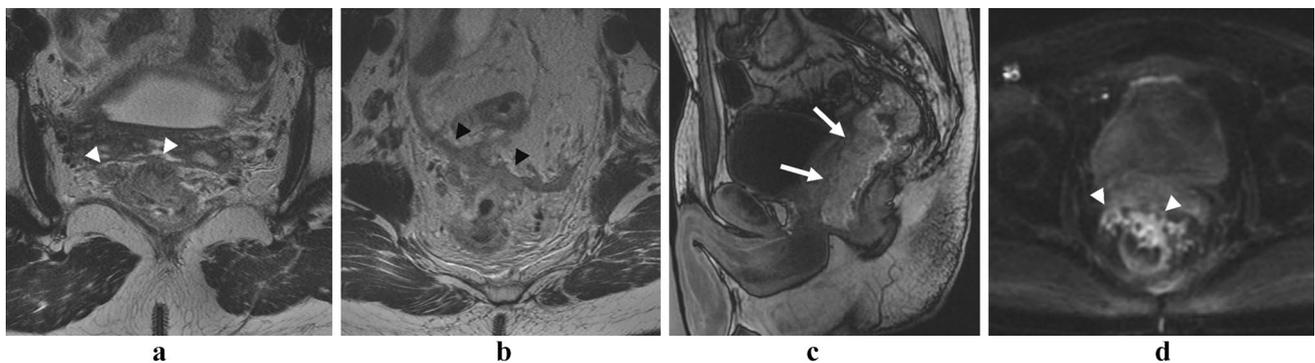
Rectal angiosarcoma secondary to radiotherapy. 27-year-old man with Li-Fraumeni syndrome and history of multiple malignancies. Axial T2-weighted (a and b), sagittal dynamic arterial phase T1-weighted (c) and diffusion-weighted (d) MR images show a large partially circumferential and infiltrative mass along anterior rectal
